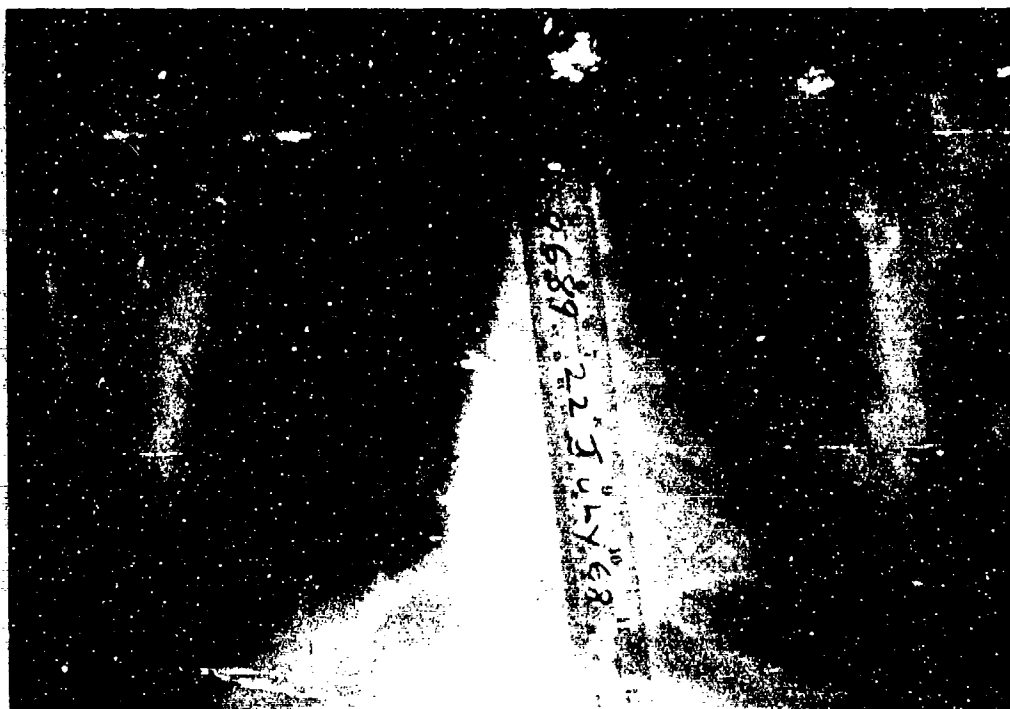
This chest roentgenogram of a soldier who was injured by blast shows bilateral infiltrates from pulmonary contusion. The patient survived without sequelae.
